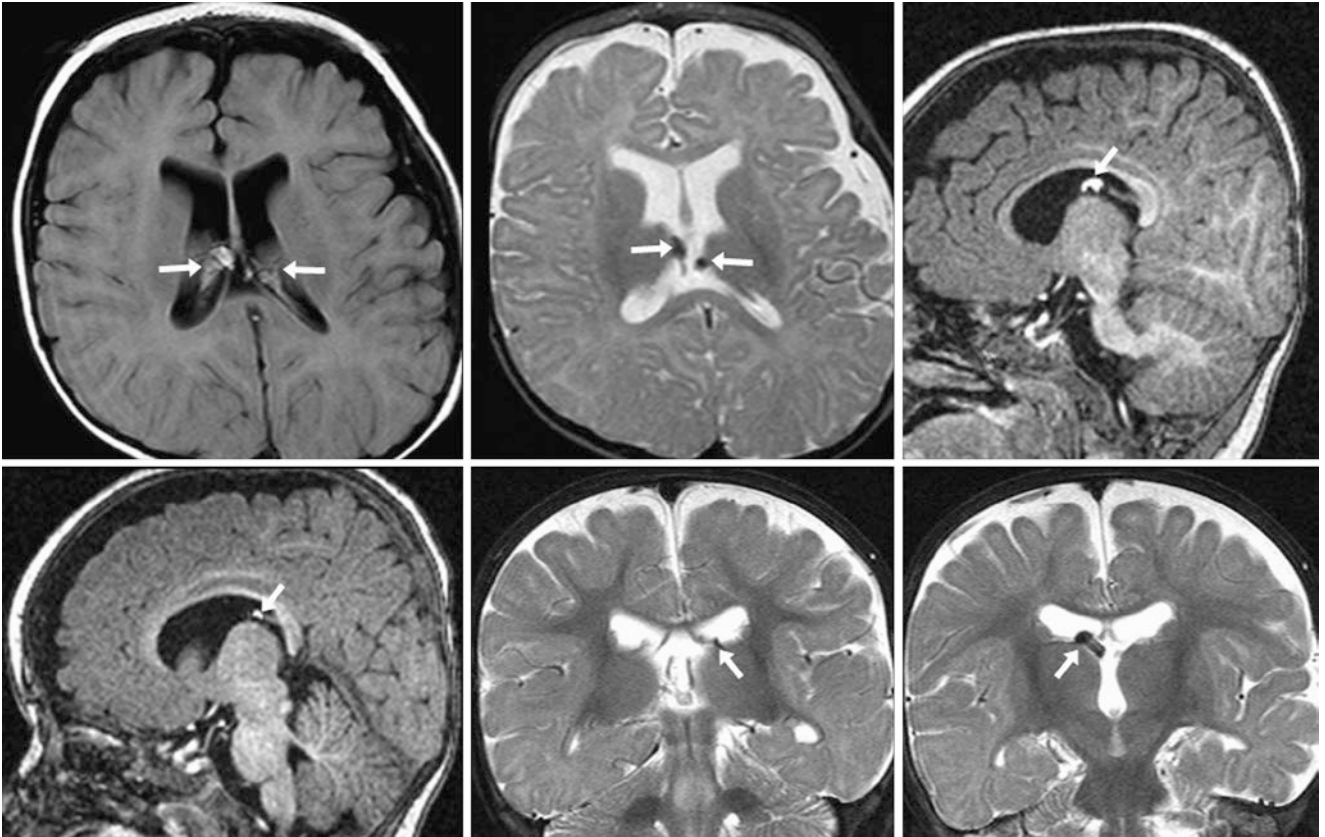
A 5 month old had an MRI demonstrating a lipoma within the choroid plexus (*arrows*) on axial FLAIR (*top left*), axial T2WI (*top middle*), sagittal T1WI (*top right and bottom left*), and coronal T2WI (*bottom middle and right*). These are usually associated with and can be
